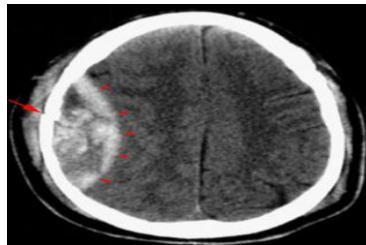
Demonstrate CT image of epidural hematoma (arrowheads) and parietal skull fracture (arrow)
